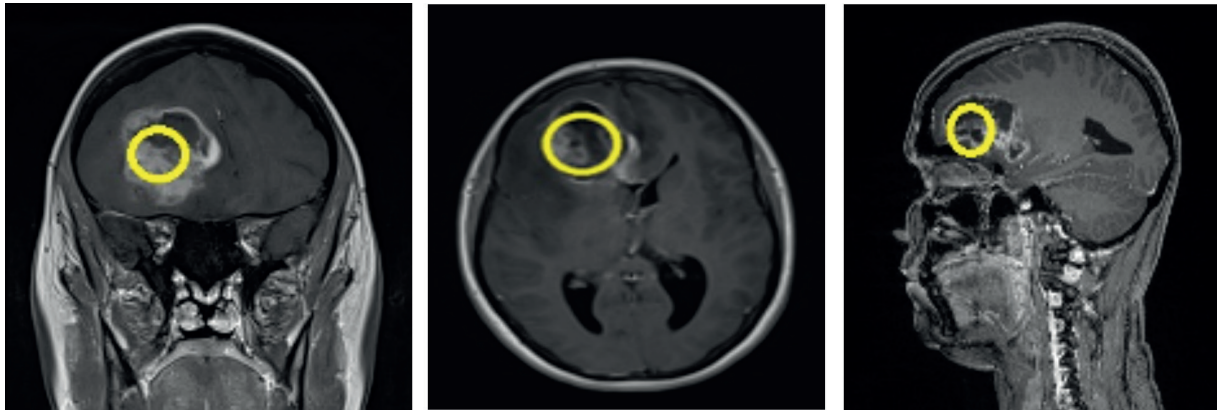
(A-C). MRI studies of lesion sites that cause incontinence and voiding difficulties in the patients studied. The yellow ellipse indicates locations where white-matter lesions have led to lasting urinary tract disorder. Here is an example of a patient with glioblastoma multiforme frontal right.
